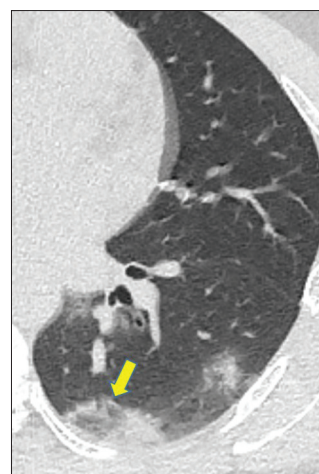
A 27-year-old male confirmed with coronavirus disease 2019 presenting with fever and myalgia for 7 days. A computed tomography scan shows a reversed halo sign (yellow arrow) in the posterior basal segment of the left lower lobe
